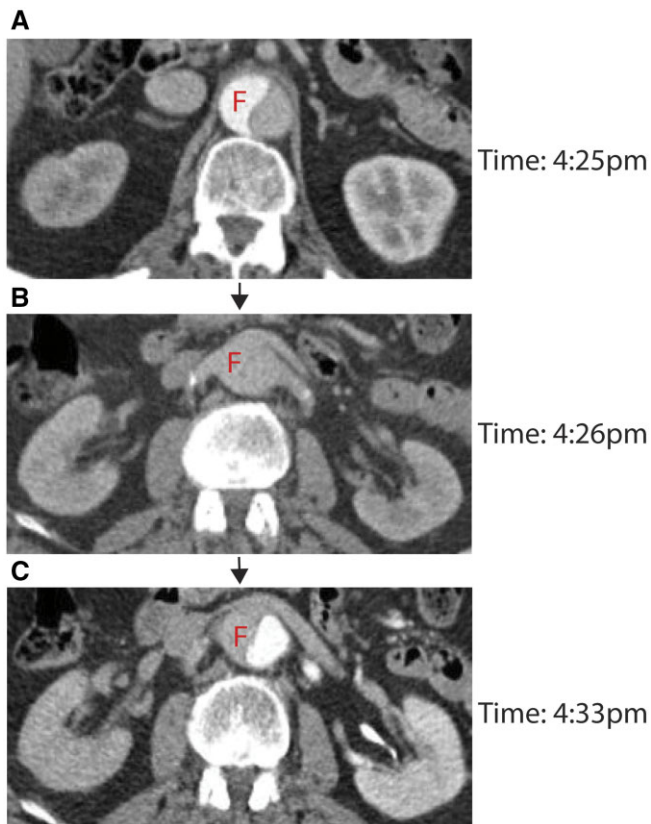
Representative example of dynamic changes in luminal enhancement due to contrast transit time in acute aortic dissection. (A) On initial angiographic images (time = 4:25 pm) the false lumen shows higher enhancement than the true lumen. (B) Approximately 1 min later (4:26 pm) enhancement of both lumens equilibrates to a low level. (C) Subsequently, the patient received another bolus of intravenous contrast and on repeat scan 7 min later (4:33 pm) the luminal enhancement pattern is reversed with the true lumen demonstrating higher enhancement. The patient underwent repair of his type A dissection, and on CT 9 years later, there was no renal atrophy. F: false lumen.
